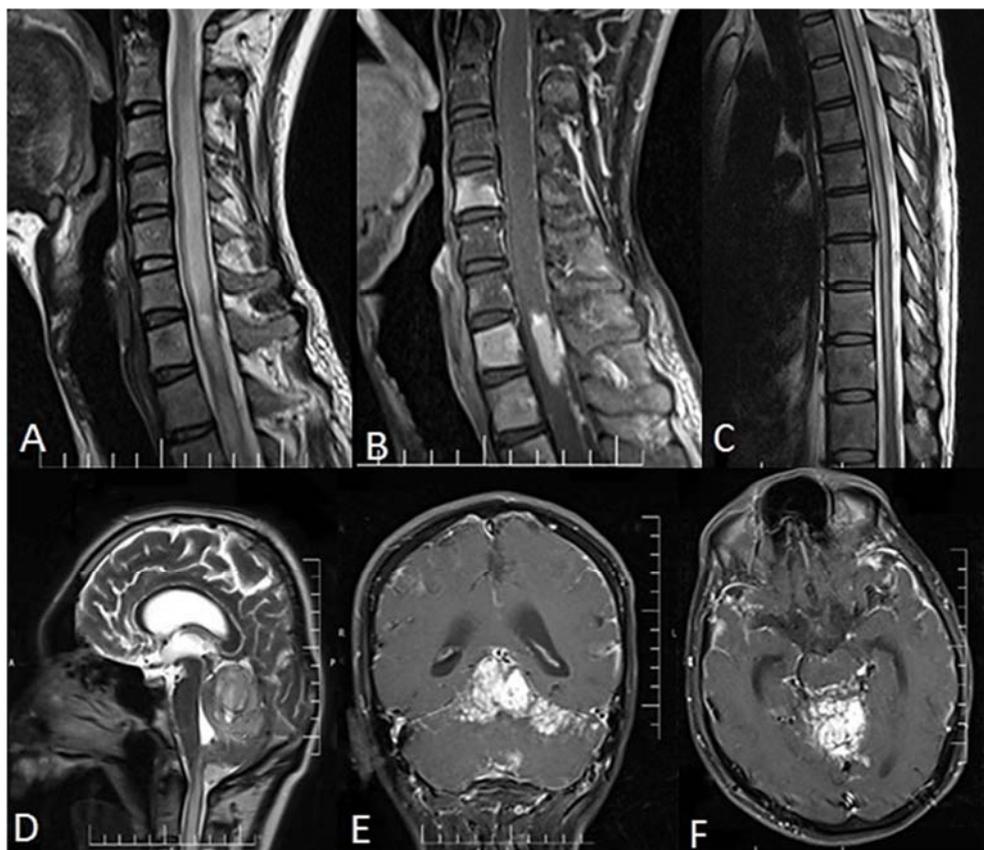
Cervical magnetic resonance imaging (MRI) showing markedly enhancing intramedullary mass with extensive leptomeningeal enhancement (A, B), diffuse syrinx formation along thoracic cord down to T10-T11 level (C), and innumerable enhancing nodules in basal cisterns with extension to posterior fossa and to sulci of cerebellar hemispheres (D, E, F)
